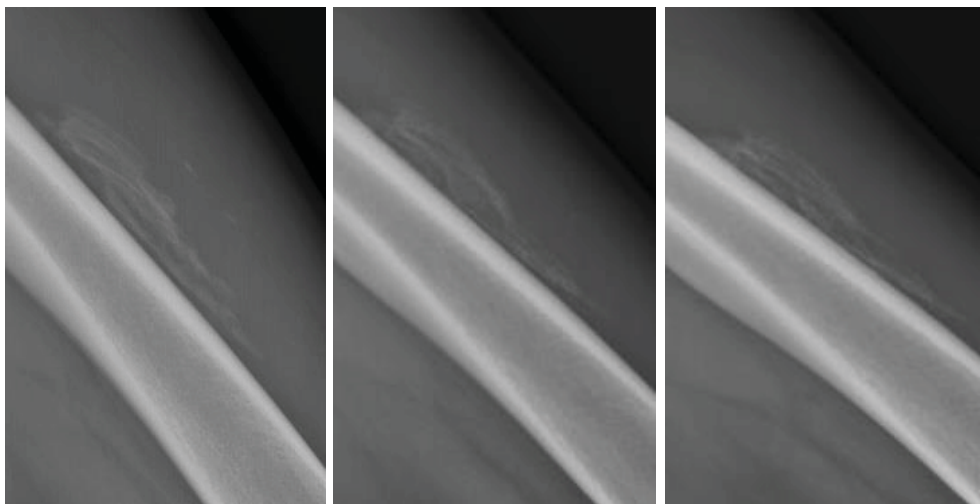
X-ray images at 4, 5, and 8 weeks from left to right.
